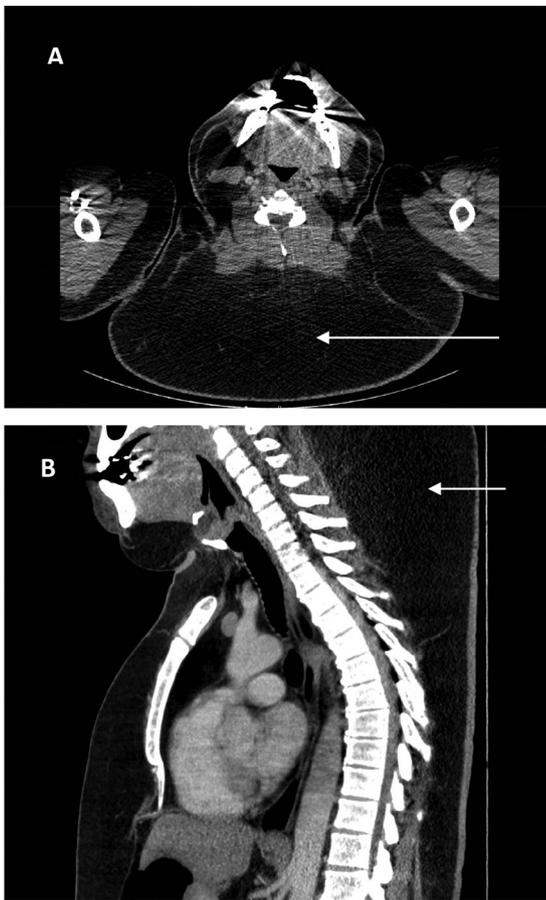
CT scan of the cervicothoracic giant lipoma in case 1, with an anteroposterior diameter of 15 cm and a transverse diameter of 30 cm. Axial (A) and sagittal (B) sections.
